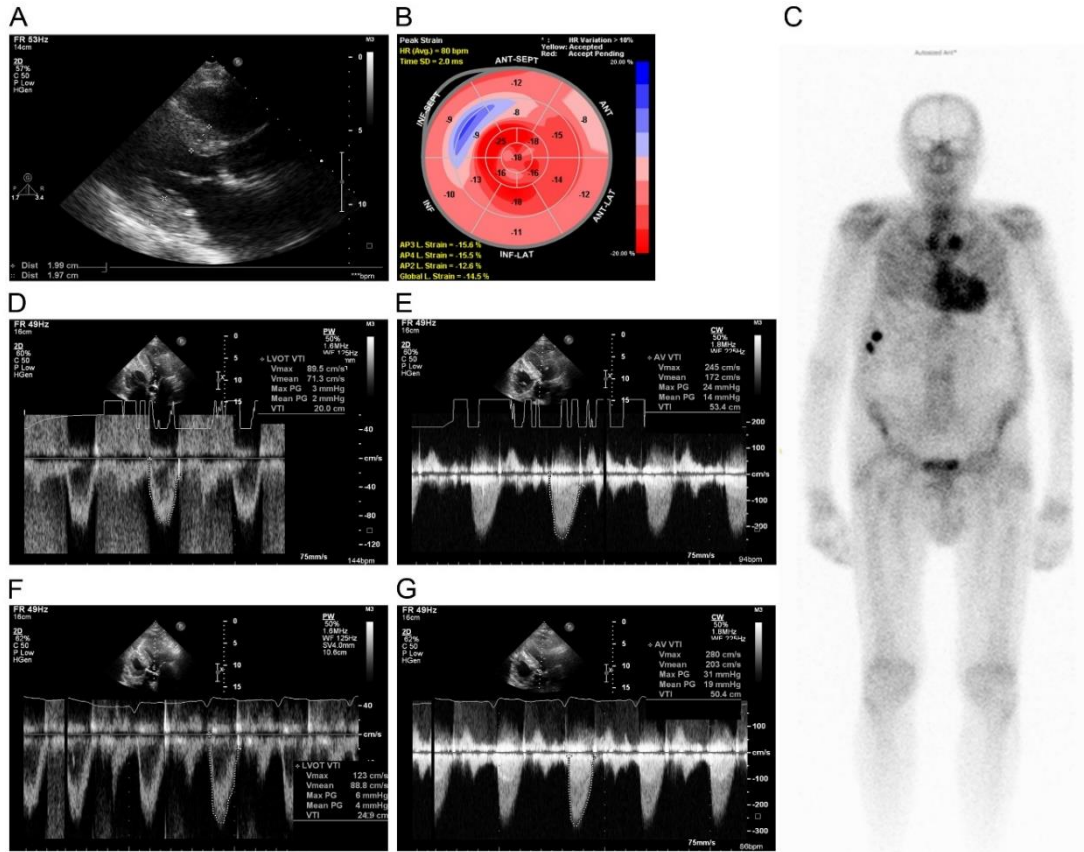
Images of a patient with ATTRwt cardiac amyloidosis and low-flow, low-gradient, pseudo-severe aortic valve stenosis. LVEF was 51%. A: Transthoracic echocardiography, parasternal long-axis view. The septum and inferior wall are 20mm thick at the end-diastole. B: Bull's s eye image of the left ventricular longitudinal strain. Typical apical sparing. C: Pyrophosphate isotope scan, with significant take-up of the tracer in the heart: Perugini score 3. D-G: Pulsed-wave (PW) and continuous-wave (CV) Doppler images of the left ventricular outflow tract at rest and at low dose dobutamine stress test. D: Resting PW Doppler, E: Resting CW Doppler. Resting calculated AVA: $0.54 \text{ cm}^2/\text{BSA}$. F: PW Doppler at dobutamine test. G: CW Doppler at dobutamine test. Significant elevation in systolic volume and AVA at the dobutamine test. Calculated AVA at dobutamine test: $0.76 \text{ cm}^2/\text{BSA}$ [55]
